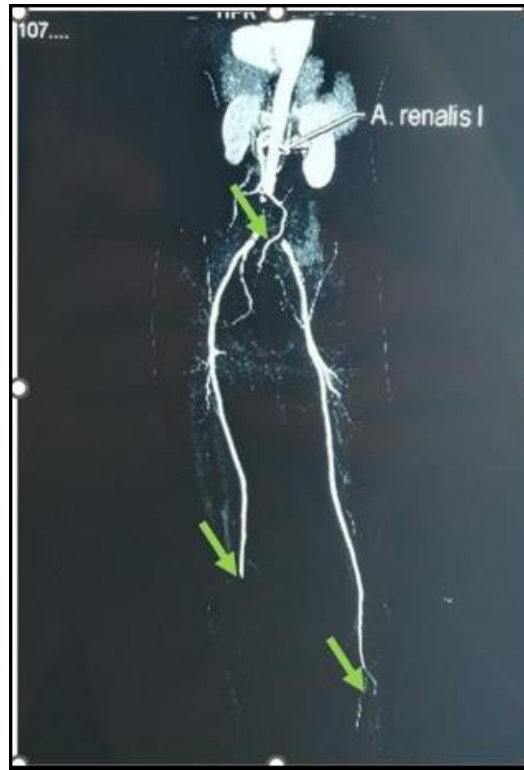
CT angiography of the aorta and iliofemoral arteries showed:
